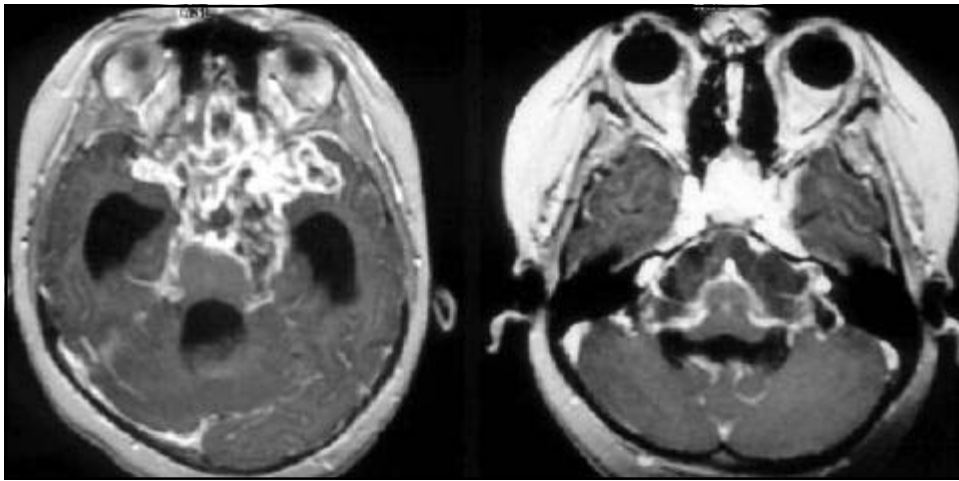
MRI Axial T1WI postcontrast (Gd-DTPA): Multiple cysts in the basal cisterns with arachnoiditis.
